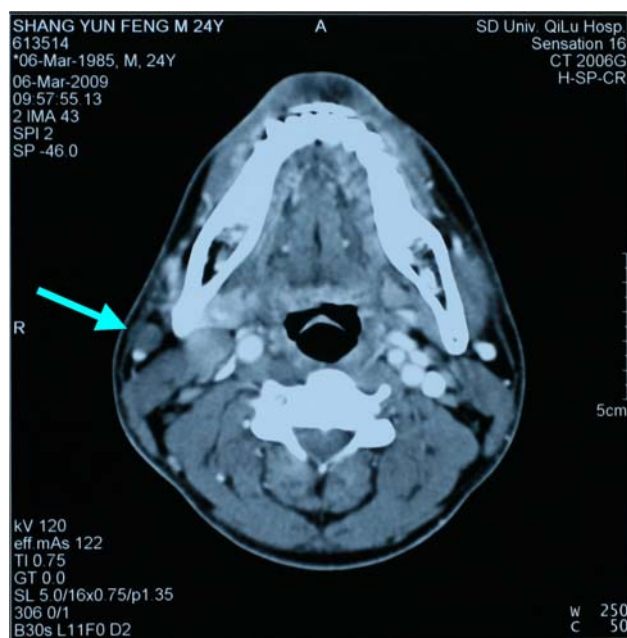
Contrast-enhanced transaxial CT showing lymph node in right cervical area (arrow)
